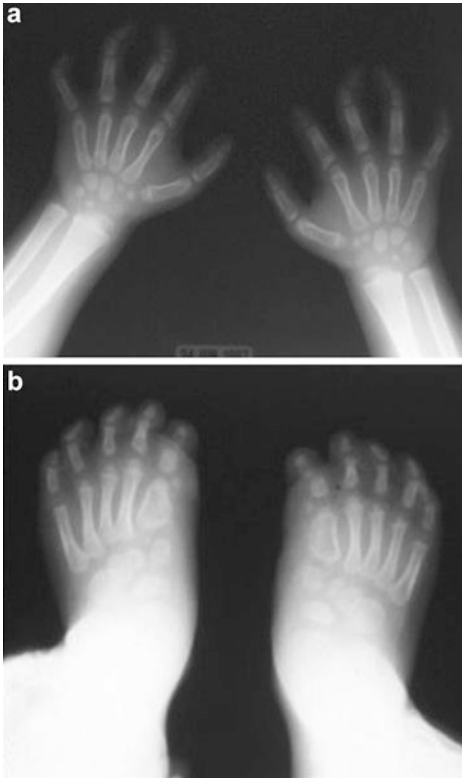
(a, b) X-ray of hands and feet
